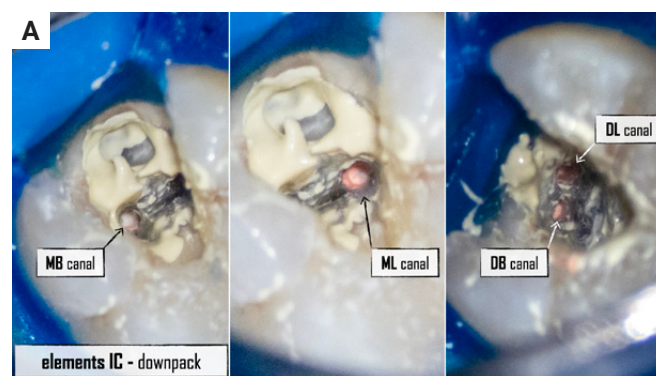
Obturation of root canals using elements™IC and continuous wave of condensation technique – A) downpack stage; B) backfill stage; C) postoperative X-ray.
